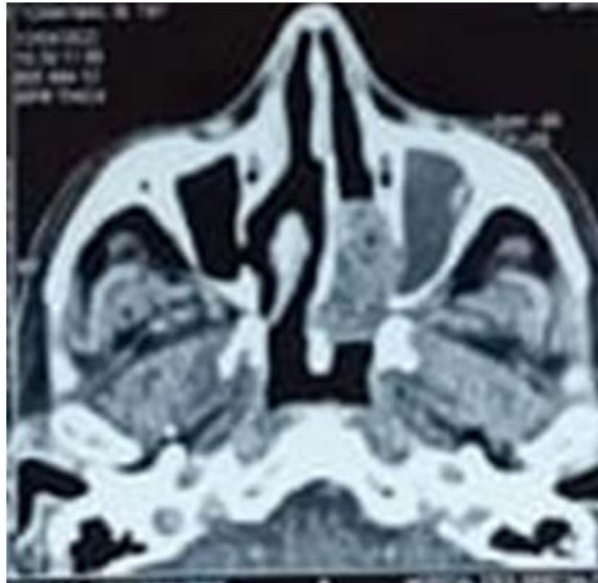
Computed tomographic scan, showing a mass in the left nasal cavity.
